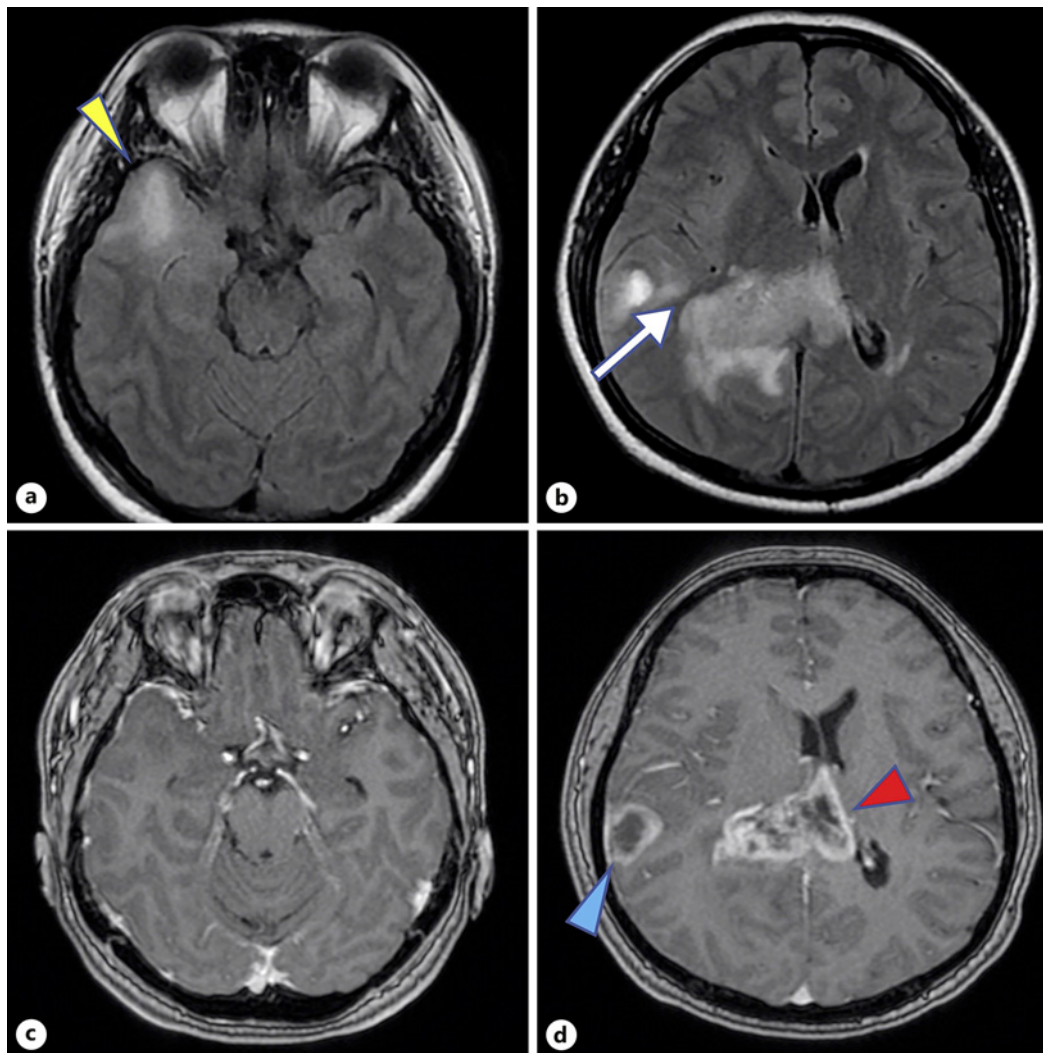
a–d Preoperative FLAIR and contrast-enhanced T1-weighted images (upper panel: FLAIR, lower panel: Gd+, right panel: enhanced lesions, left panel: non-enhanced lesion) showing the three lesions, which are highlighted by three arrowheads; yellow arrowhead: lesion (1), blue arrowhead: lesion (2), red arrowhead: lesion (3). The white arrow indicates a lack of continuity between lesions (2) and (3) in a FLAIR image. FLAIR, fluid attenuated inversion recovery; Gd, gadolinium.
